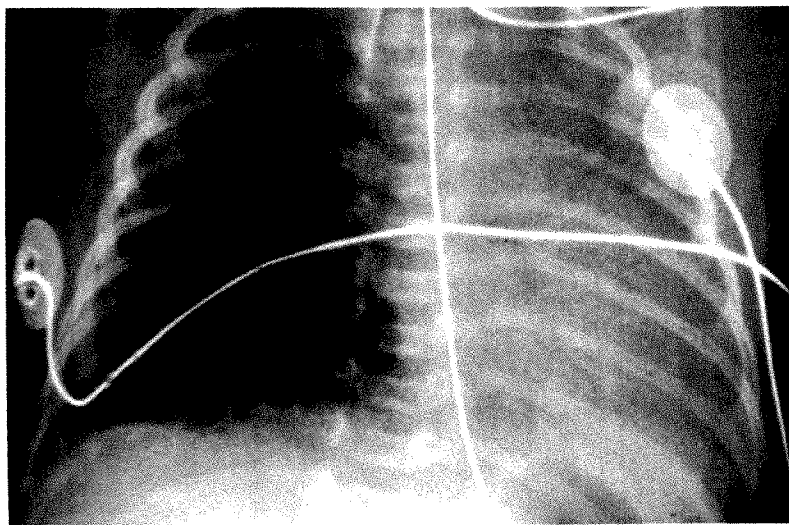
Chest radiograph shows selective clearing of respiratory distress syndrome in right lung 6 hr after surfactant administration.
